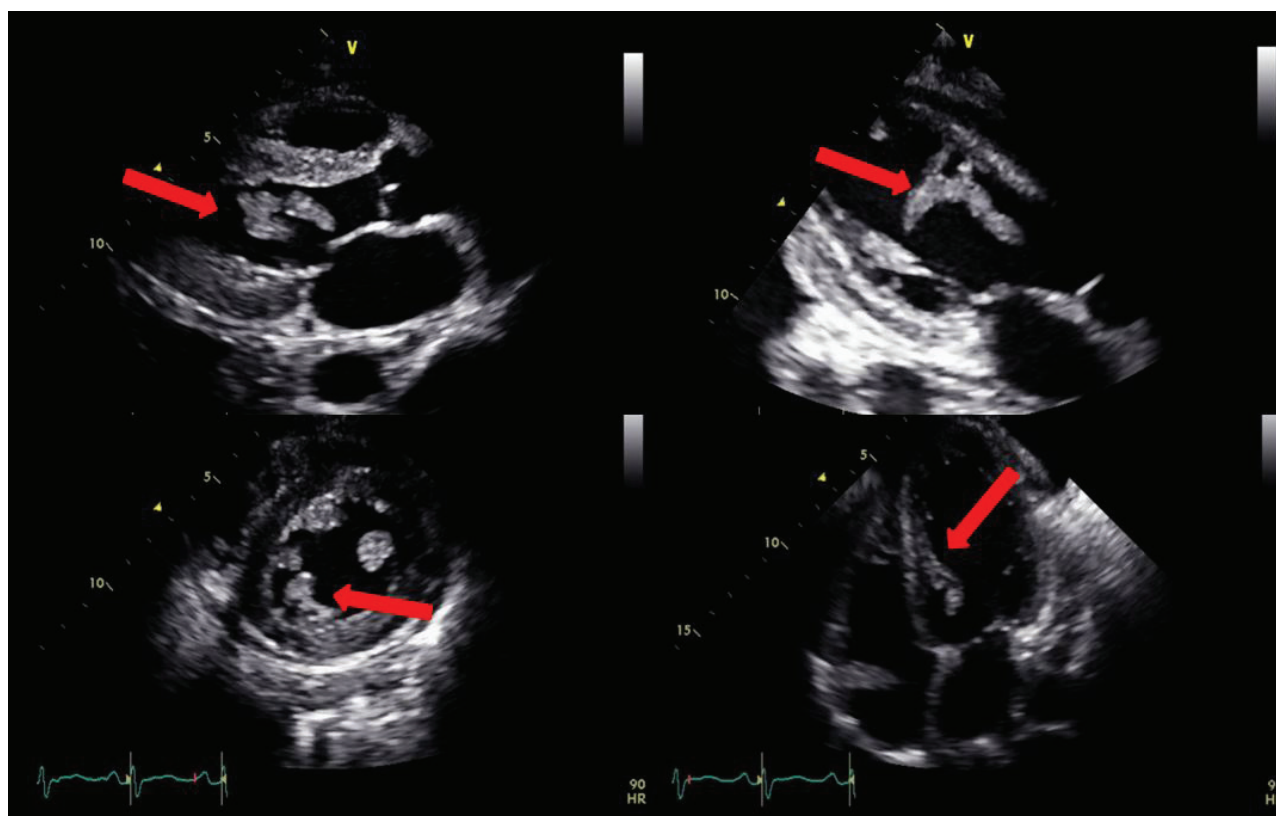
Transthoracic echocardiography showing oscillating mass-like lesions at the mid anteroseptal wall of the left ventricle (arrows). The heart chamber size and systolic function were normal.
